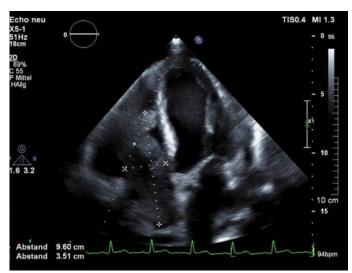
Echocardiography four- chamber view. Huge mass in the right atrium expanding to the right ventricle.
